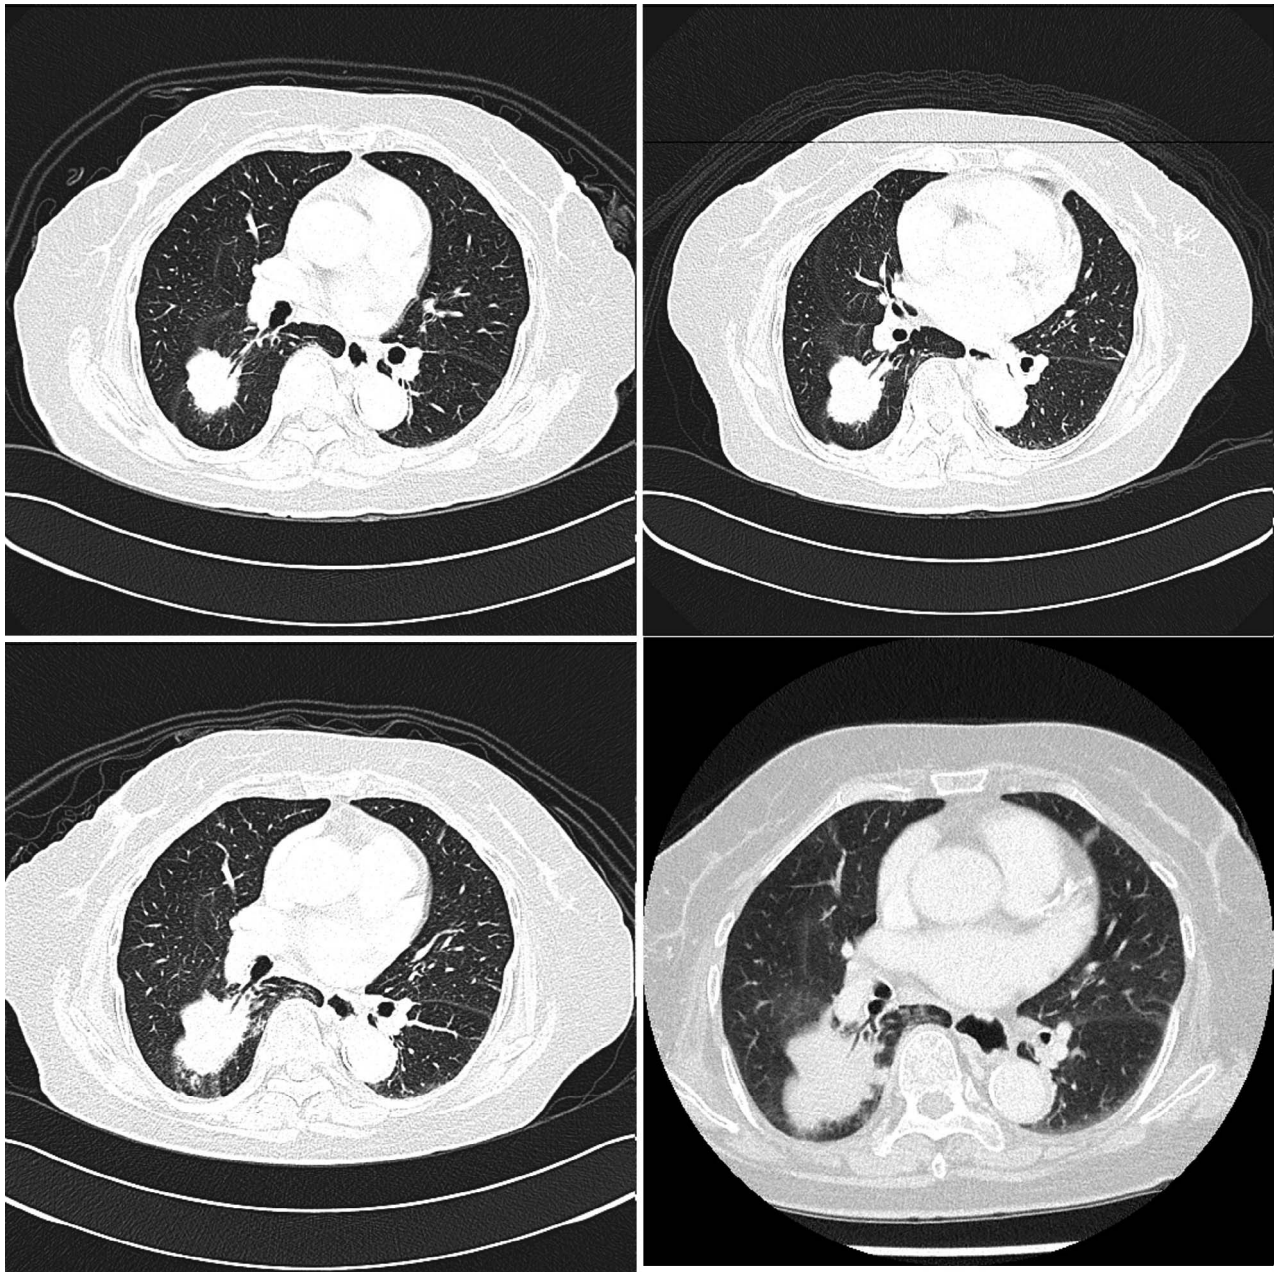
Change of CT scan of chest (top left taken on March 24, 2010, top right on June 4, 2012, bottom left on October 14, 2013, and bottom right on October 2, 2014).
